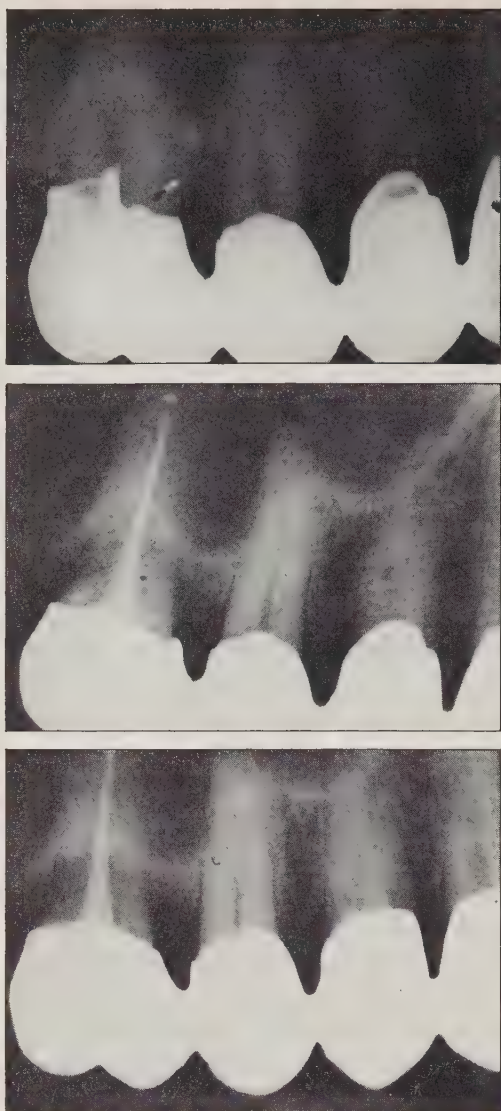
(a) Severe periodontal involvement, upper first molar. (b) Vital amputation of both buccal roots, followed by root canal therapy (radiographic appearance 6 months later). (c) Same tooth 10 years later.
